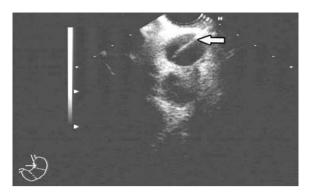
The patient underwent EUS-FNA (arrow) as shown. EUS-FNA - endoscopic ultrasonography-fine needle aspiration
